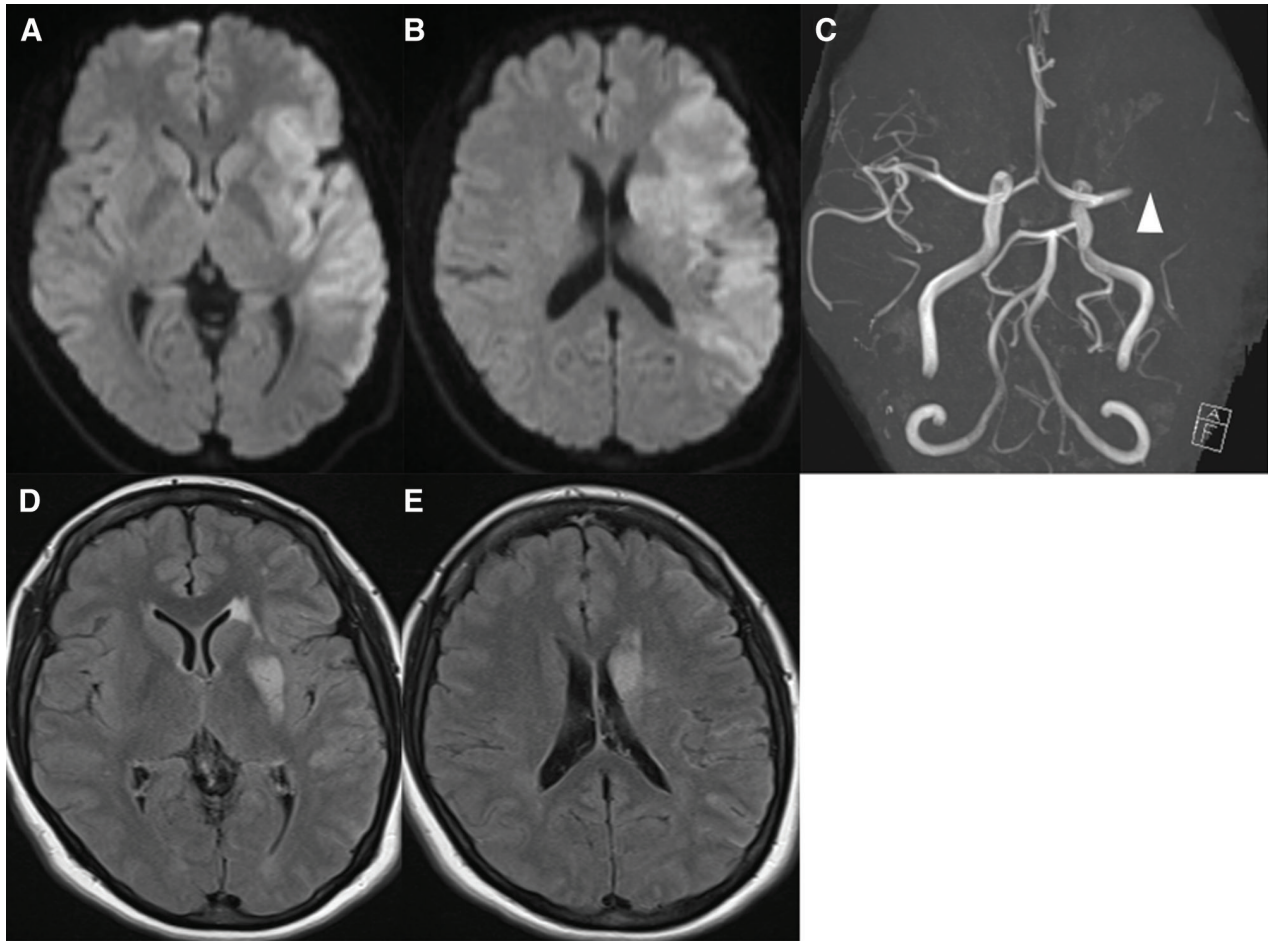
(A and B) DWIs show acute stroke on the left hemisphere (DWI-ASPECTS is 3). (C) MRA shows disruption of the left middle cerebral artery at the M1 segment (white arrowhead). (D and E)
